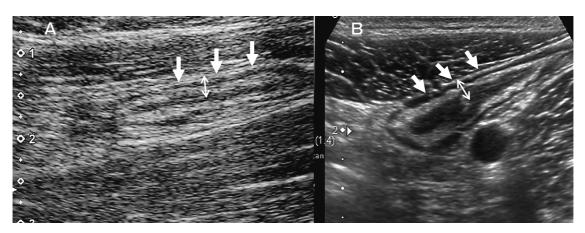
US findings (sigmoid colon, 7.5 MHz). A, TUS findings of a bowel wall thickness of 1.5 mm (mucosa without inflammation); B, US findings of a bowel wall thickness of 3.7 mm (mucosa with inflammation). The sigmoid colon (white arrows) is indicated, along with the representative measurement method (two-headed white arrows). TUS, trans abdominal ultrasonography.
